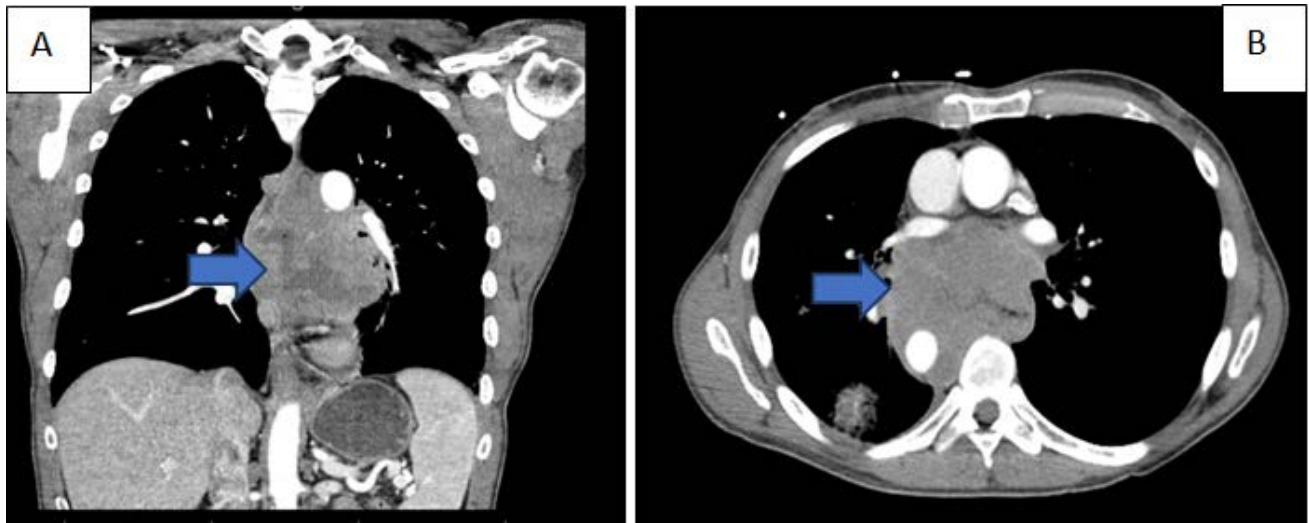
CT scan of the chest showing an 8.8 x 8.6 x 10.3 cm esophageal mass causing a mass effect on adjacent structures without evidence of invasion
